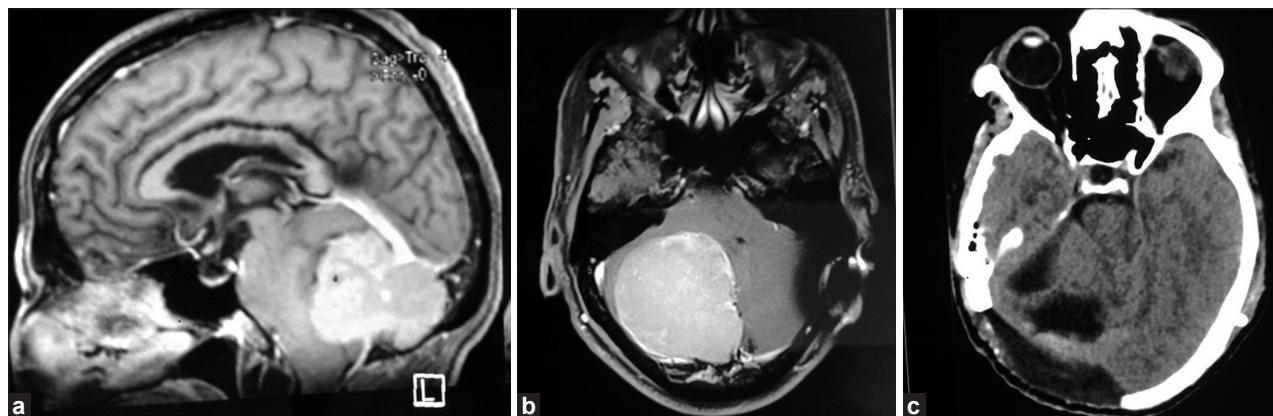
Tentorial meningioma with postoperative CT scan
